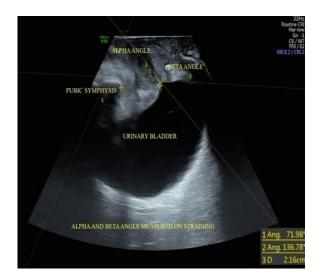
α and β angles measured by transperineal ultrasonography during straining.
